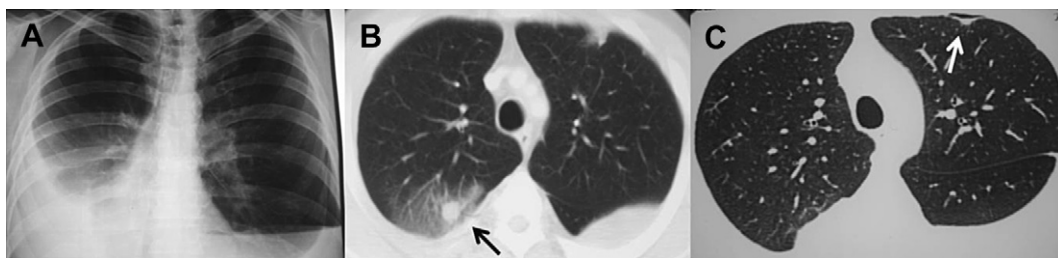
(Patient 2): The forty five years old Turkish male patient was admitted to hospital with cough. He had a three years history of seropositive RA and he was admitted to our hospital with suffered from chronic cough. He had also receiving immunosuppressive treatment. The performed chest radiography showed the bilateral pleural effusion. The thorax CT revealed the bilateral pleural effusion, nodular lesions and necrobiotic nodular lesions. Also, ground glass opacity was observed around the nodular lesion in thorax CT.
